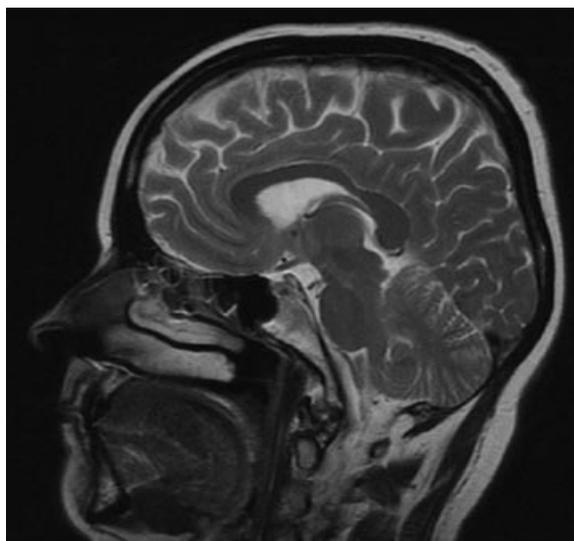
MRI, T2-weighted image, sagittal projection: tiny anomaly of callosal shape – thinning of posterior part of callosal body.
